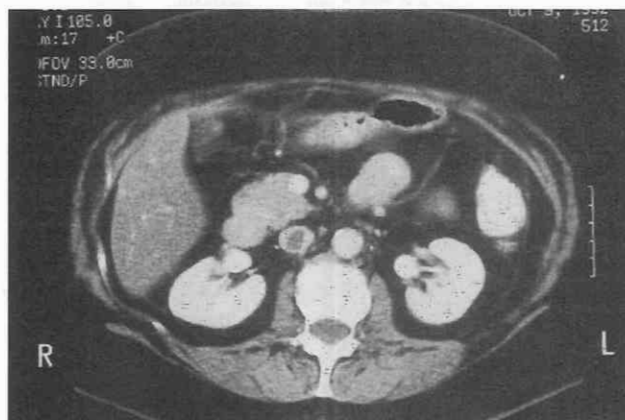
Inferior vena cava (IVC) thrombus. Dynamically enhanced CT scan shows the margin between the clot and the wall of the IVC to be sharply defined. Delayed images would not reveal any significant change in this appearance.
